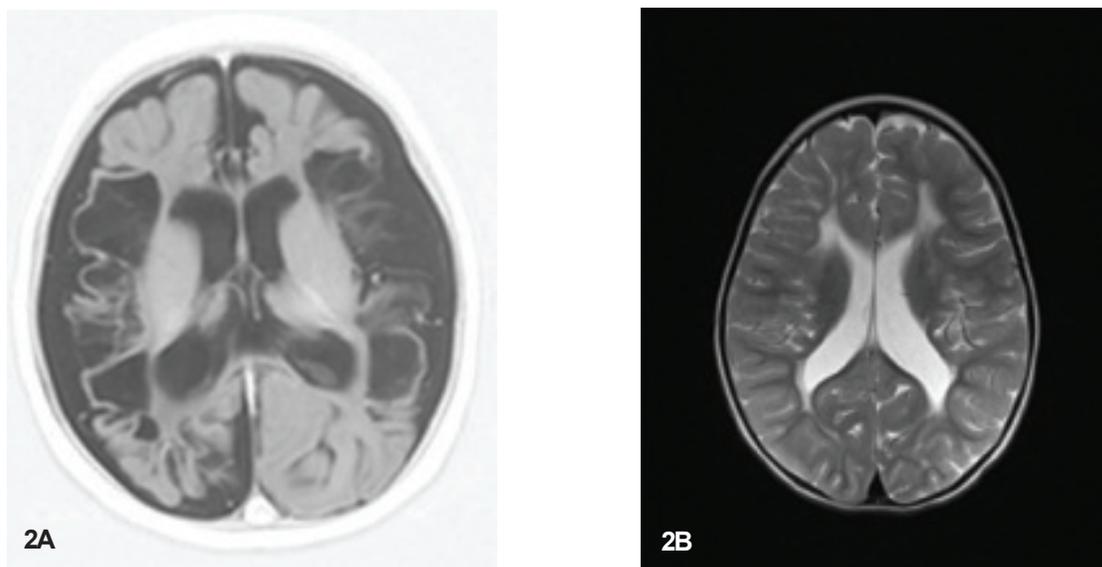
MRI of brain, coronal sections showing (A) multicysticencephalomalacia (T1 weighted image), (B) Periventricular leucomalacia (PVL) (T2 weighted image)
